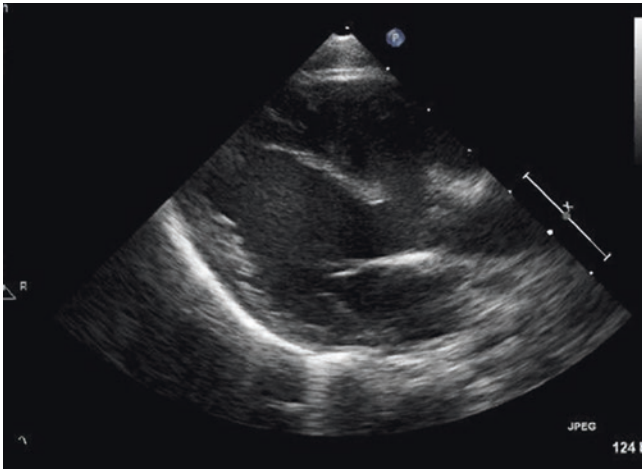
Parasternal long-axis echocardiogram view of a patient with unrepaired tetralogy of Fallot. Note the large ventricular septal defect and overriding aorta. *Ao* Aorta, *LV* Left ventricle, *VSD* Ventricular Septal Defect
